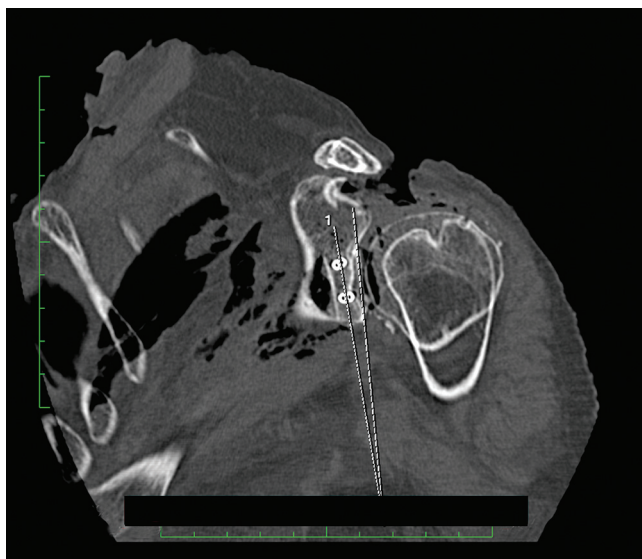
Superimposition of 2 sagittal computed tomography images to measure the angle between the major axes of the glenoid and the coracoid graft.
